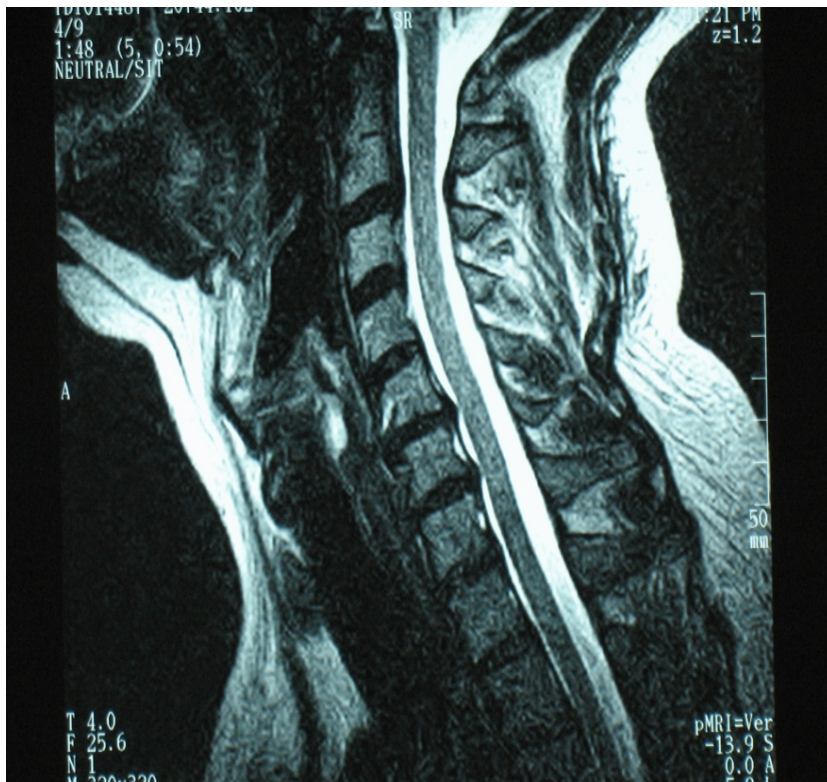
Cervical spine MRI, sagittal view.
